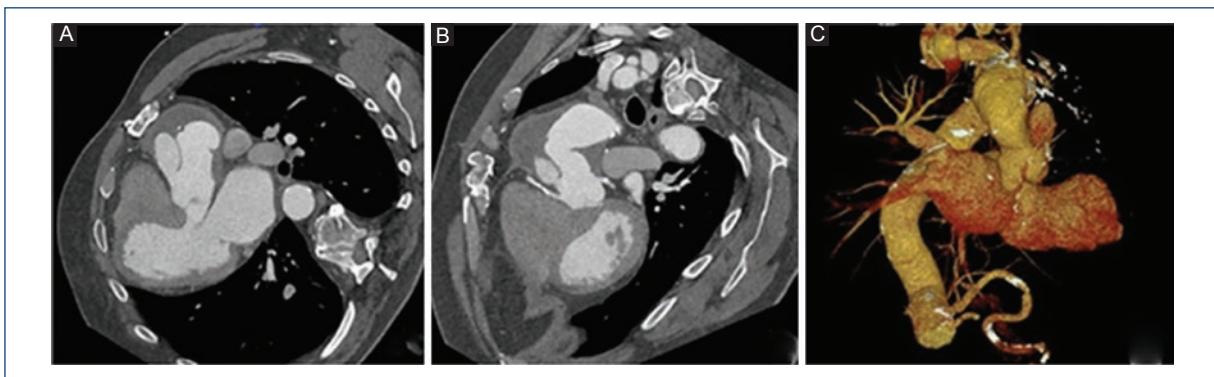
A-C: Aortic computed tomography (MPR LVOT, aortic root and ascending aorta, and 3DVR image) showing aortic pseudoaneurysm of the aortic root closed to the right coronary sinus.
